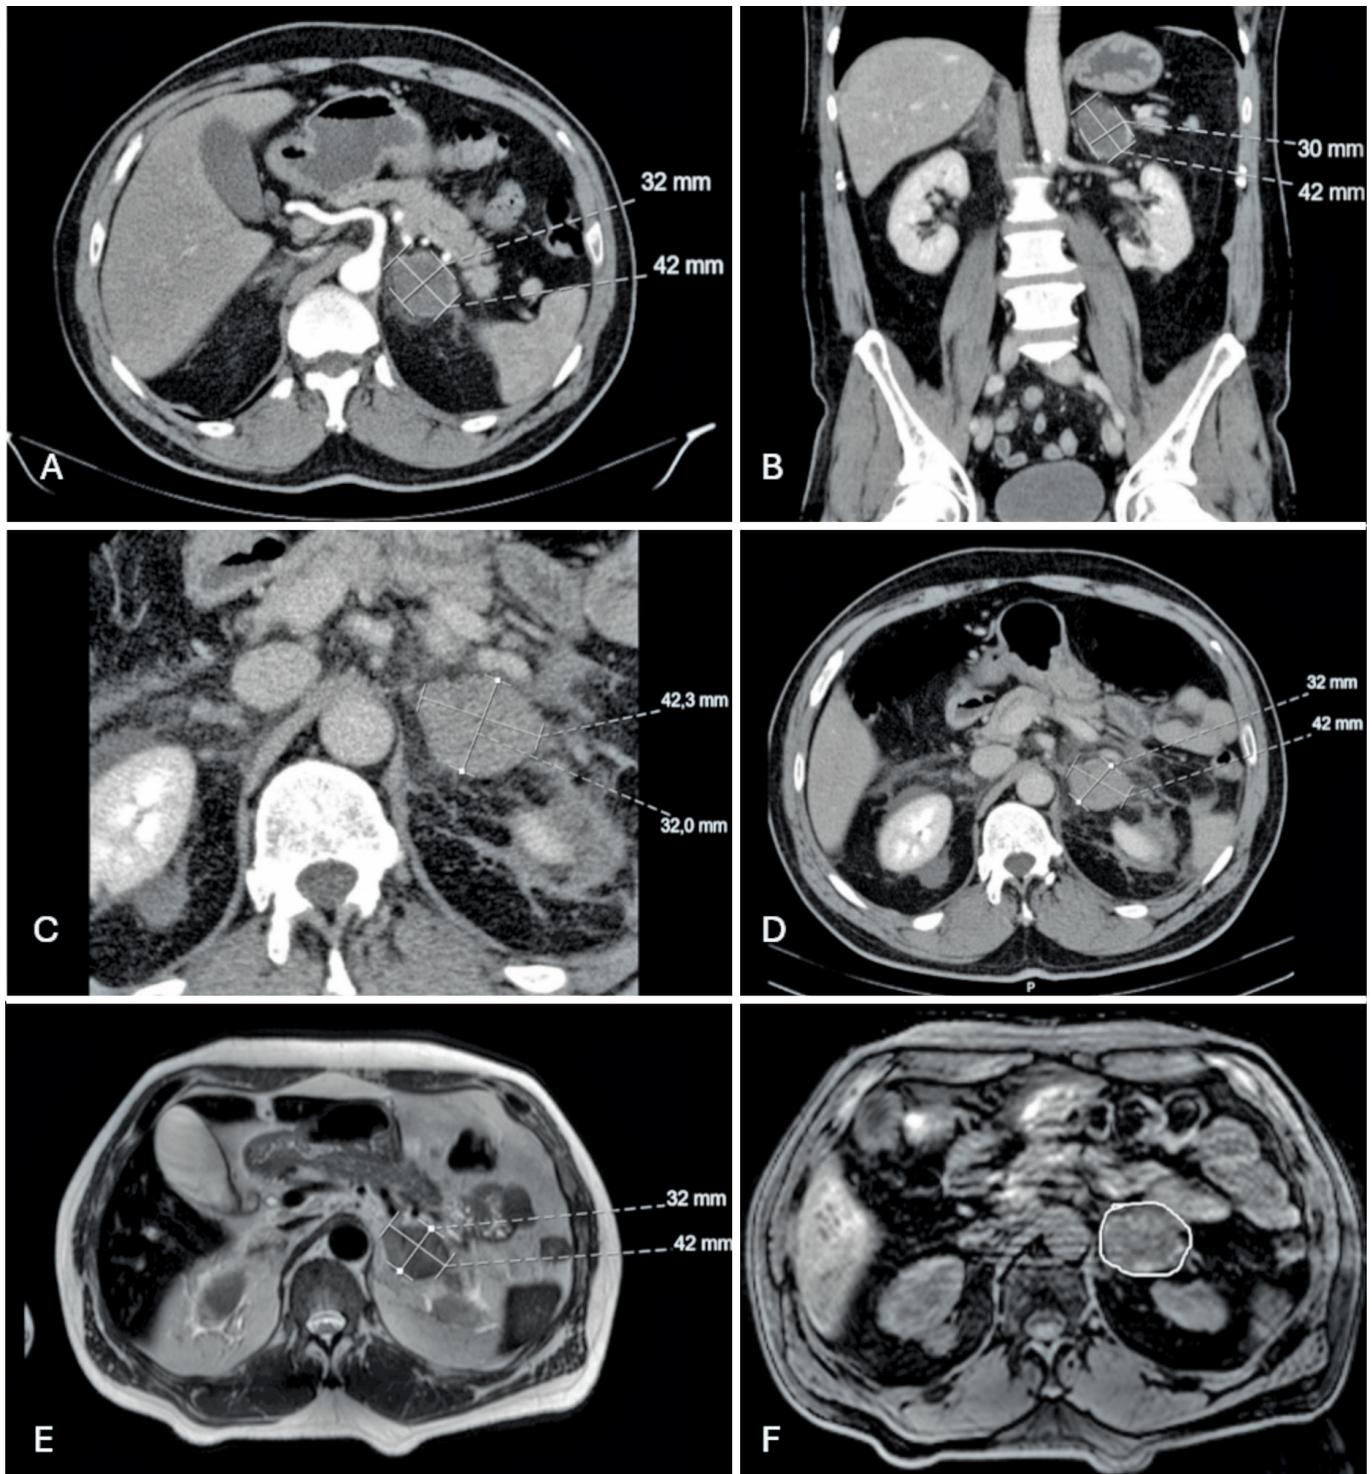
Case 2 – A and B. Admission axial and coronal CT of left adrenal hematoma; C and D. Follow-up axial CT (five days later) showing the hematoma with surrounding fat stranding; E. T1-weighted fat-saturated MRI demonstrating hyperintense hemorrhagic content; F. T2-weighted MRI showing hypointense areas consistent with subacute blood.
